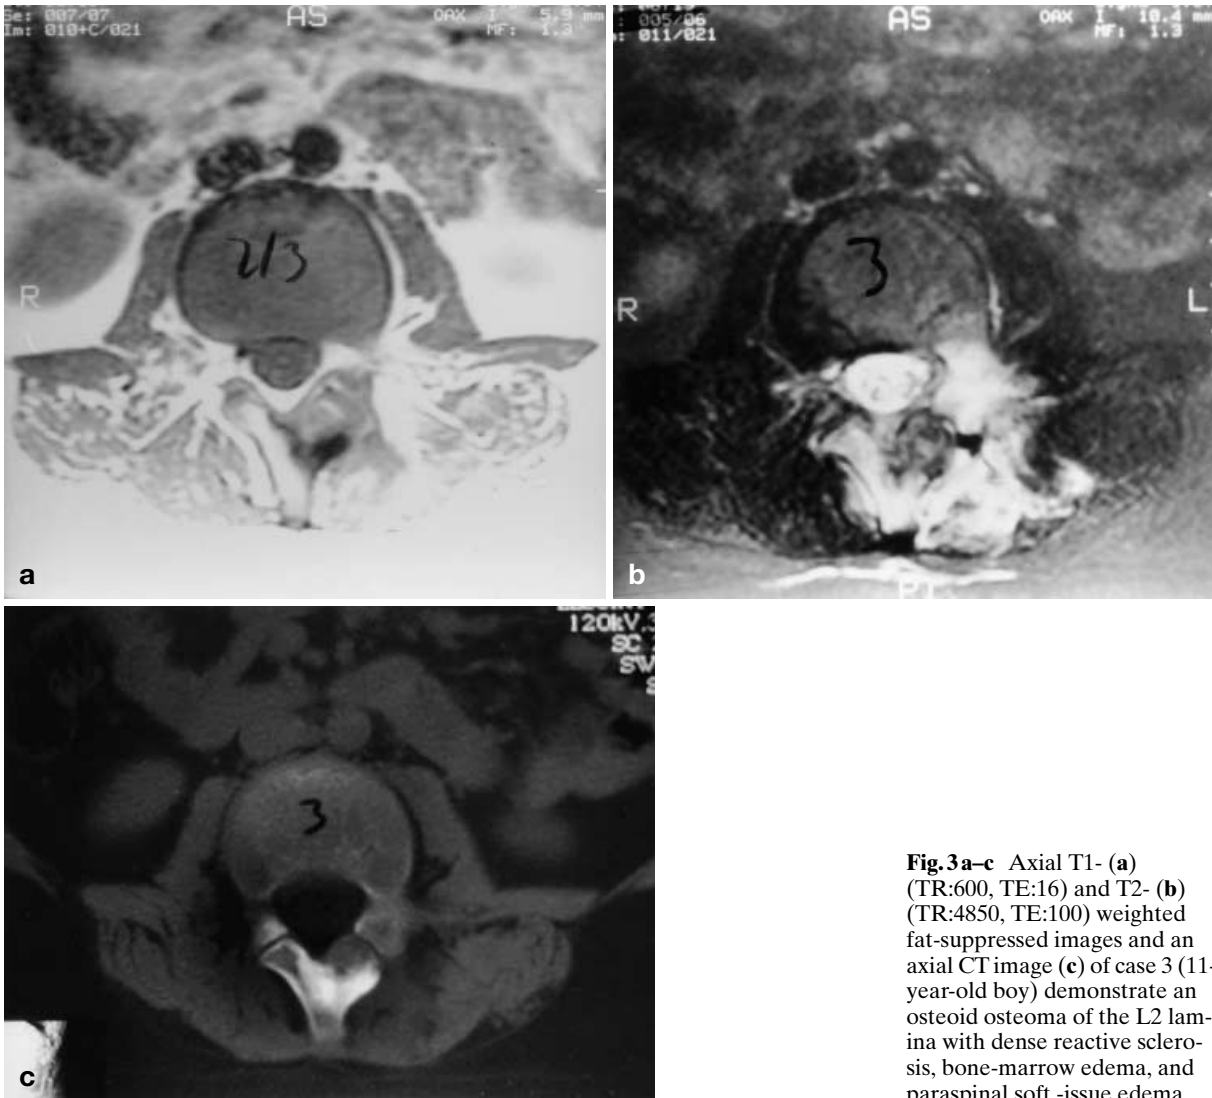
Axial T1- (a) (TR:600, TE:16) and T2- (b) (TR:4850, TE:100) weighted fat-suppressed images and an axial CT image (c) of case 3 (11-year-old boy) demonstrate an osteoid osteoma of the L2 lamina with dense reactive sclerosis, bone-marrow edema, and paraspinal soft-tissue edema
